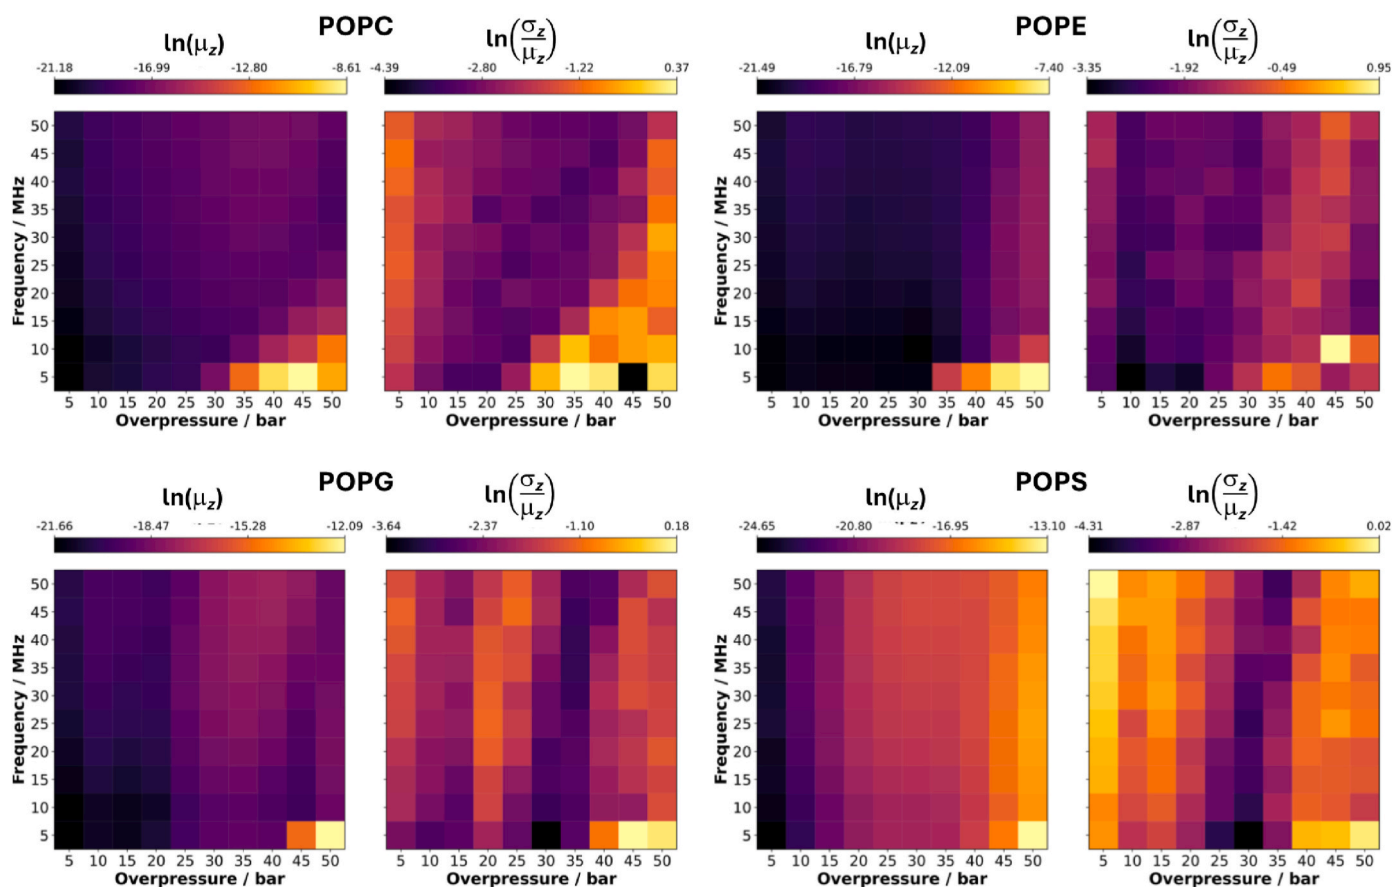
Thickness (z) response for the studied systems under varying ultrasound conditions. Two heatmaps are plotted for each lipid bilayer: Logarithm of mean thickness, $\ln(\mu_z)$, showing average membrane expansion or compression (left); and Logarithm of relative z fluctuations, $\ln(\frac{\sigma_z}{\mu_z})$, indicating the magnitude of z variations relative to its average value (right). Color scale: Blue indicates lower values, red higher values. This logarithmic representation enhances visibility of subtle variations across different ultrasound parameter regimes. (For interpretation of the references to colour in this figure legend, the reader is referred to the Web version of this article.)
